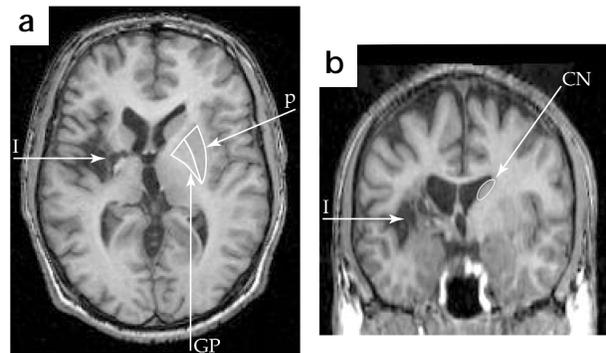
T1-weighted MR images showing a left hemisphere infarction involving the posterior part of the anterior insula, posterior insula, internal capsule, putamen and globus pallidus. (a) Axial image. (b) Coronal image also shows damage to the head of the caudate nucleus. The intact right putamen (P) and intact right globus pallidus (GP; a) and intact right head of caudate (CN; b) are outlined. White arrow, insula lesion (I).
